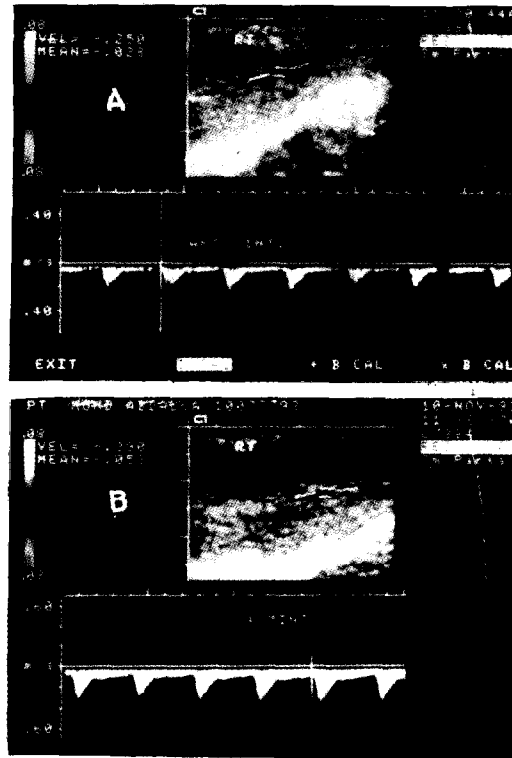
Value of extending the doppler test to 20-30 min. A) Peak flow velocity in the right cavernosal artery 5 min. was 25 cm/sec. B) Peak systolic velocity 14 min. later was 39 cm/sec. denoting normal arterial in flow.
